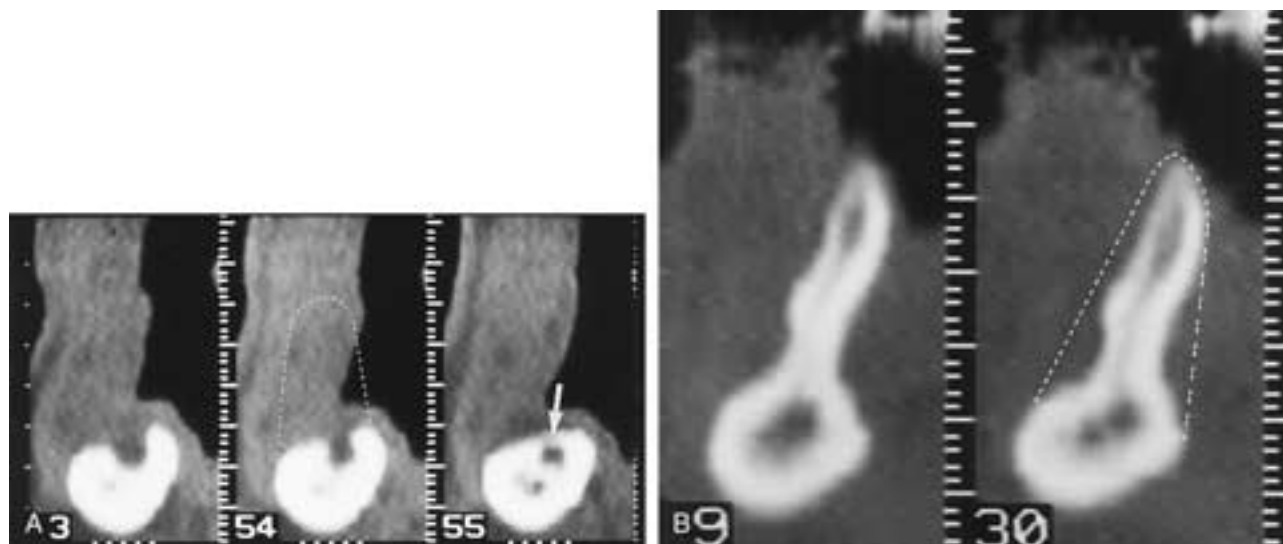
Cross-sectional views of the mandible in two different patients demonstrating bone resorption and atrophy. A, Bone loss and atrophy of the height of the mandible in this patient cause the mandibular canal (arrow) to sit immediately under the gingival surface. The dotted line demonstrates how the bone contour might have appeared before atrophy. The patient has insufficient bone for implants. (From Abrahams JJ. The role of diagnostic imaging in dental implantology. *Radiol Clin North Am* 1993;31(1):163–180.) B, The width of the mandible in this patient has been considerably diminished due to atrophy. The dotted line again demonstrates how the bone might have appeared before atrophy. (From Abrahams JJ. CT assessment of dental implant planning. *Oral Maxillofac Surg Clin North Am* 1992;4:1–18.)
